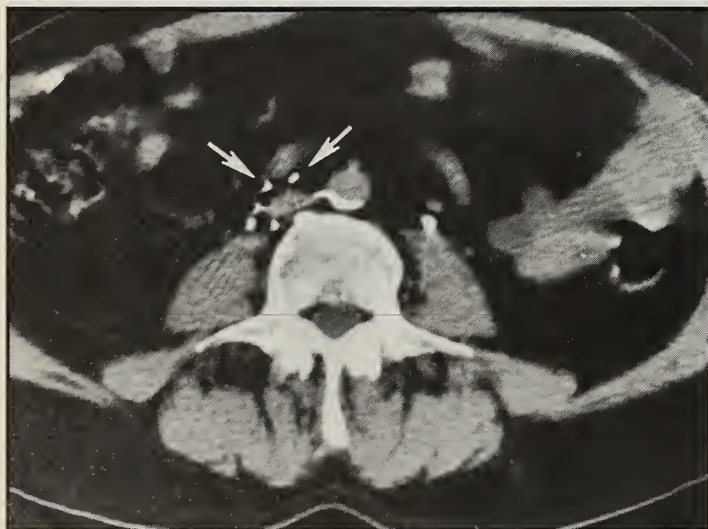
Computed tomography of the abdomen reveals penetration of the IVC by all filter legs (arrows).
